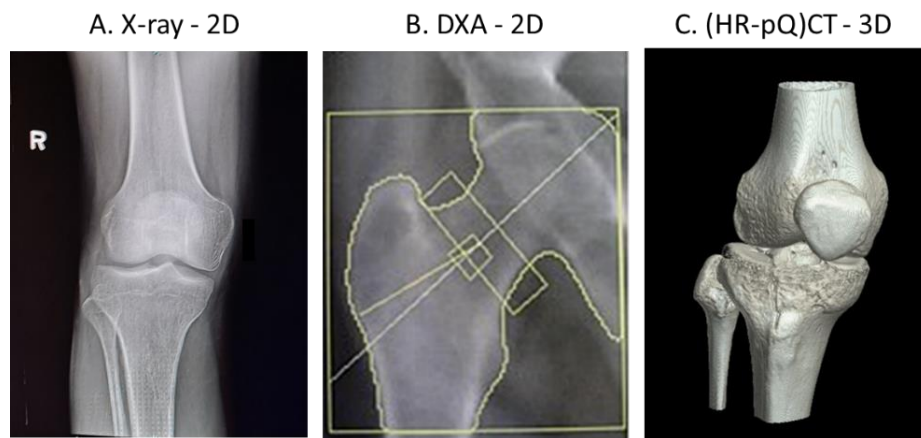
Radiographic medical images (note soft tissues absence). Taken from Wikimedia Commons^{310,311}.
